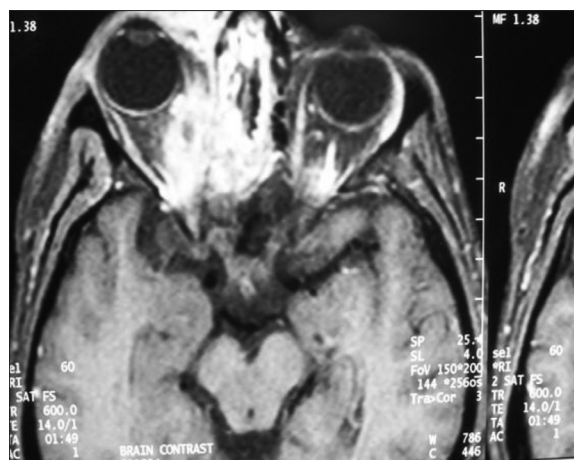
CT of the brain with orbital section showing an abnormal heterogeneous soft tissue swelling with post-contrast enhancement involving the right ethmoid gallery with extra- and intraconal orbital extension
